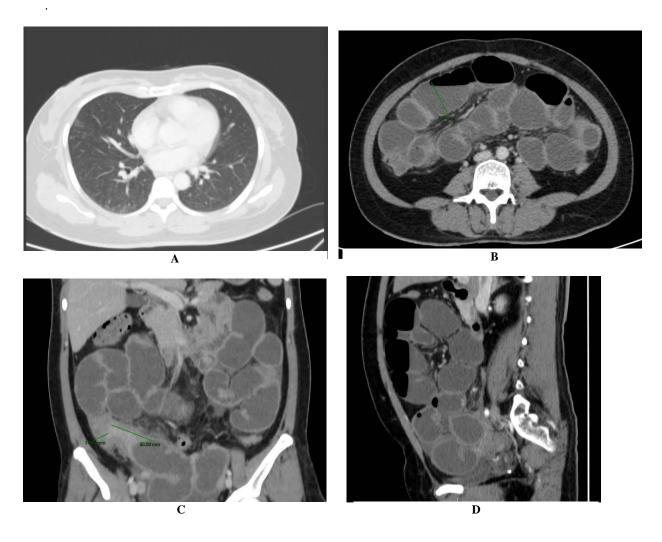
Thoracic abdominopelvic computed tomography: A: no lung lesions, B & D: multiple dilated loops of small bowel. C: Lesion of terminal ileum at right lower quadrant.
